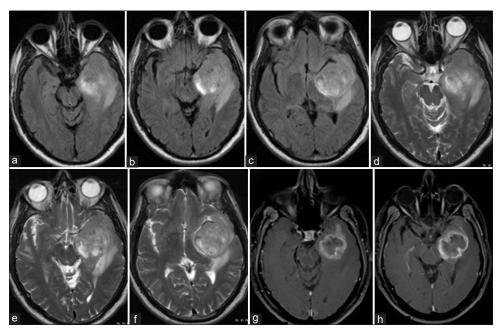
Sequential axial FLAIR (a-c), T2w (d-f) and post-contrast T1-weighted (g and h) MRI done after 8 Wk showing a further increase in the area of involvement of the abnormal high signal intensity in the left medial temporal lobe with an increase in the size of the ring-enhancing lesion at the site of the original abnormality in the previous MRI. The mass effect has also increased with new-onset left uncal herniation FLAIR = Fluid-attenuated inversion recovery; MRI = Magnetic resonance imaging
